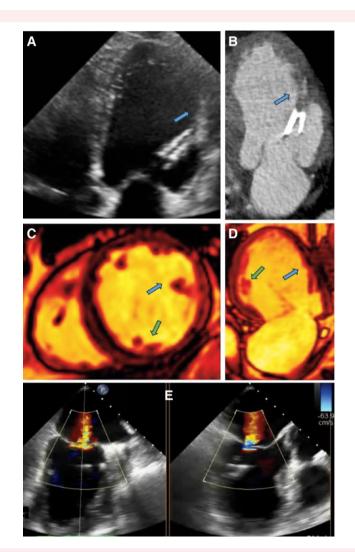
Transthoracic four-chamber view (A) shows an echo-rich double-contour structure connected to the anterolateral papillary muscle (blue arrow) and both mitral valve leaflets, confirmed as calcified marginal chordae tendineae by cardiac computed tomography (B). The anterolateral papillary muscle was the dominant papillary muscle on cardiac magnetic resonance imaging (C, D), in contrast to the smaller posteromedial muscle (green arrow), pointing to parachute-like mitral valve morphology with moderate mitral regurgitation (E) of mixed cause, predominantly functional.
